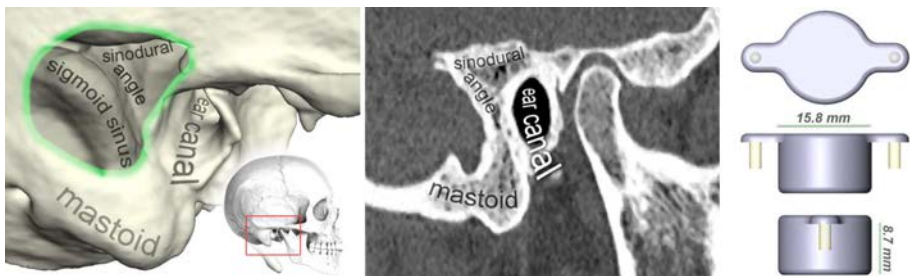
Anatomy of the temporal bone (left) and a corresponding CT slice (middle). FMT geometry with screw positions indicated as yellow cylinders (right).
